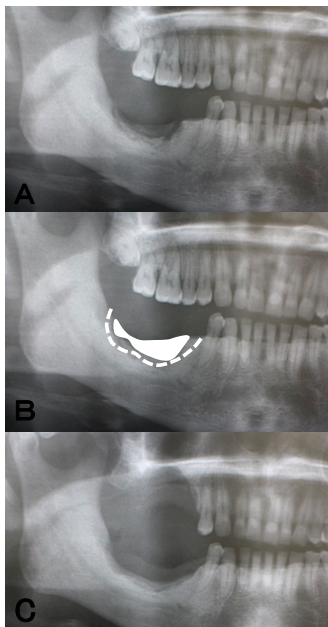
Panoramic X-ray pictures showing the bone resection area. A: Preoperating findings showing the necrotic lesion at right lower molar region. B: A scheme of the bone resection area. Broken line shows resection line. C: Postoperating findings after bone resection.
